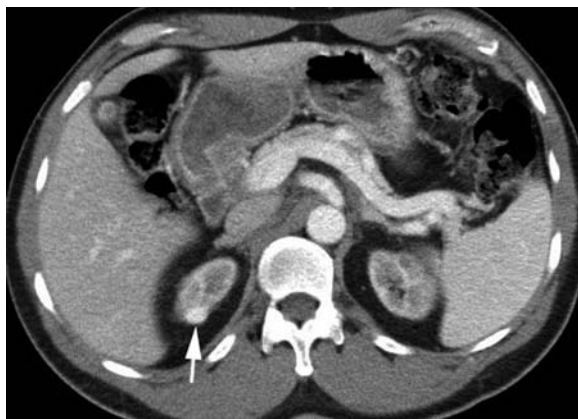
End-stage renal disease in a 57-year-old woman on dialysis with hematuria. a Axial contrast-enhanced CT scan shows a homogeneously enhancing 7 mm nodule in the right upper pole (*arrow*). b Axial contrast-enhanced CT scan at mid-kidney level shows a heterogeneously enhancing nodule within a partially cystic mass posteriorly (*arrow*) and a poorly enhancing mass medially (*arrowhead*); all three were clear cell carcinomas. (With permission from CURRY 2002)
